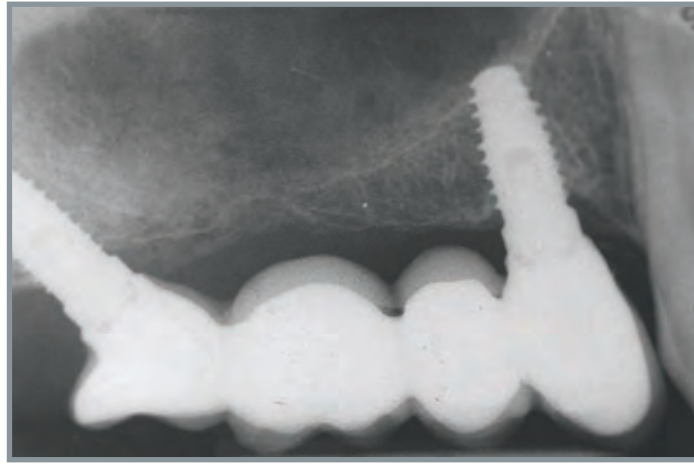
Three-year control. Periapical radiograph.
